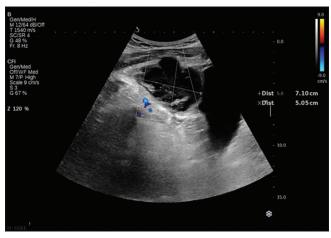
Ultrasound showing an irregular, lobulated, cystic lesion with content of mixed echogenicity located at the dome of the bladder
